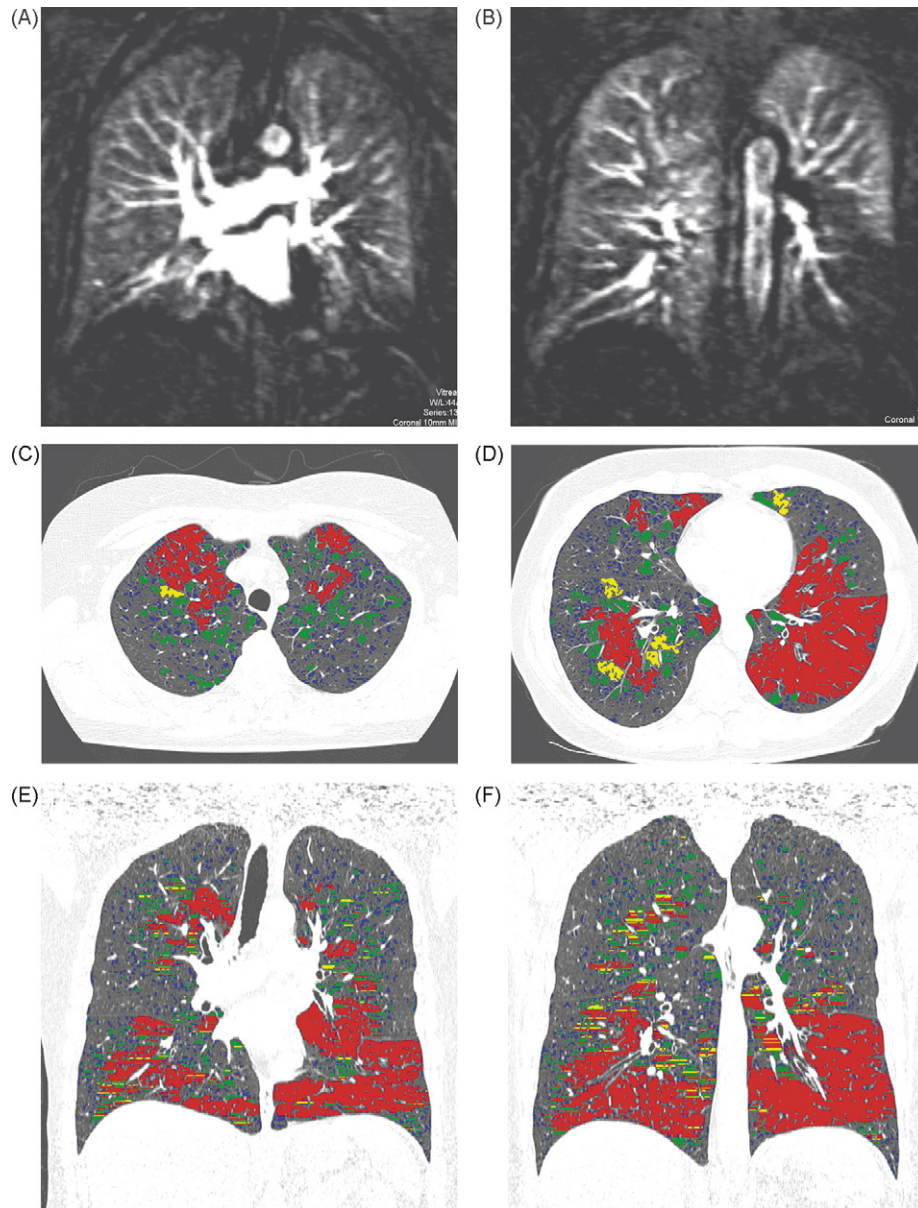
Fifty-two years old female patient suffering from emphysema GOLD class 3 (FEV_1 predicted 47%) with smoking history of 40 packyears. Ten millimeters ventral and dorsal Dataset_{MRP} of coronal lung perfusion MR images (A and B): the upper and middle lobe on the right were scored 1. The right lower lobe was scored 2. On the left we scored 2, 3 and 4 for upper, middle and lower lobe, respectively. Color map of two original axial CT images (C and D) and coronal images ventral and dorsal (E and F): clusters class 4 (red), class 3 (yellow), class 2 (green) and class 1 (blue). The right lung was scored 2 for each lobe. On the left we scored 2, 3 and 4 for upper lobe, lingula and lower lobe, respectively.
